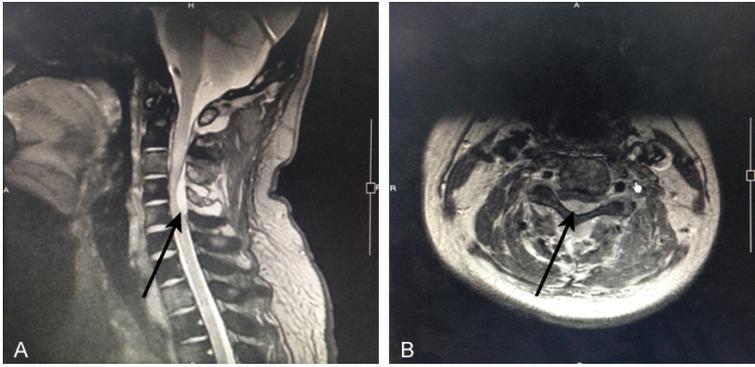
Radiological findings: Sagittal T1-WI (A) and axial T2-WI (B) of MRI revealed an intraspinal mass with a protrusion into the medullary cavity (arrow). MRI: magnetic resonance imaging.
